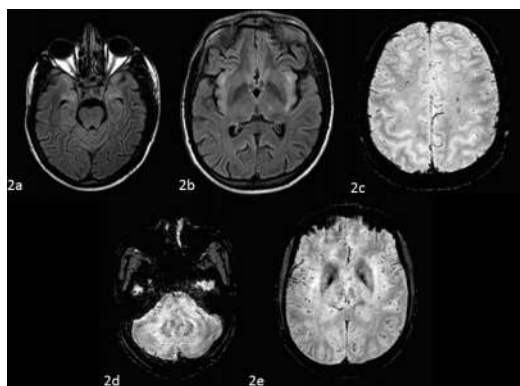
2b- Axial FLAIR MRI Brain showing hyperintensities of symmetrical insular and medial temporal regions, Fig 2c-2e- Axial SWI MRI Brain showing mineralisation of symmetrical deep grey nuclei and dentate nuclei of cerebellum
